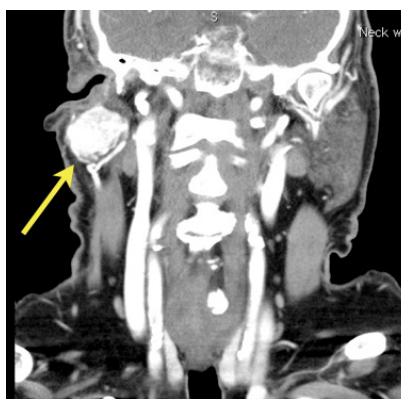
Axial and coronal views of a CT scan with contrast of the neck demonstrating a vascular lesion within the superficial aspect of the right parotid gland.
